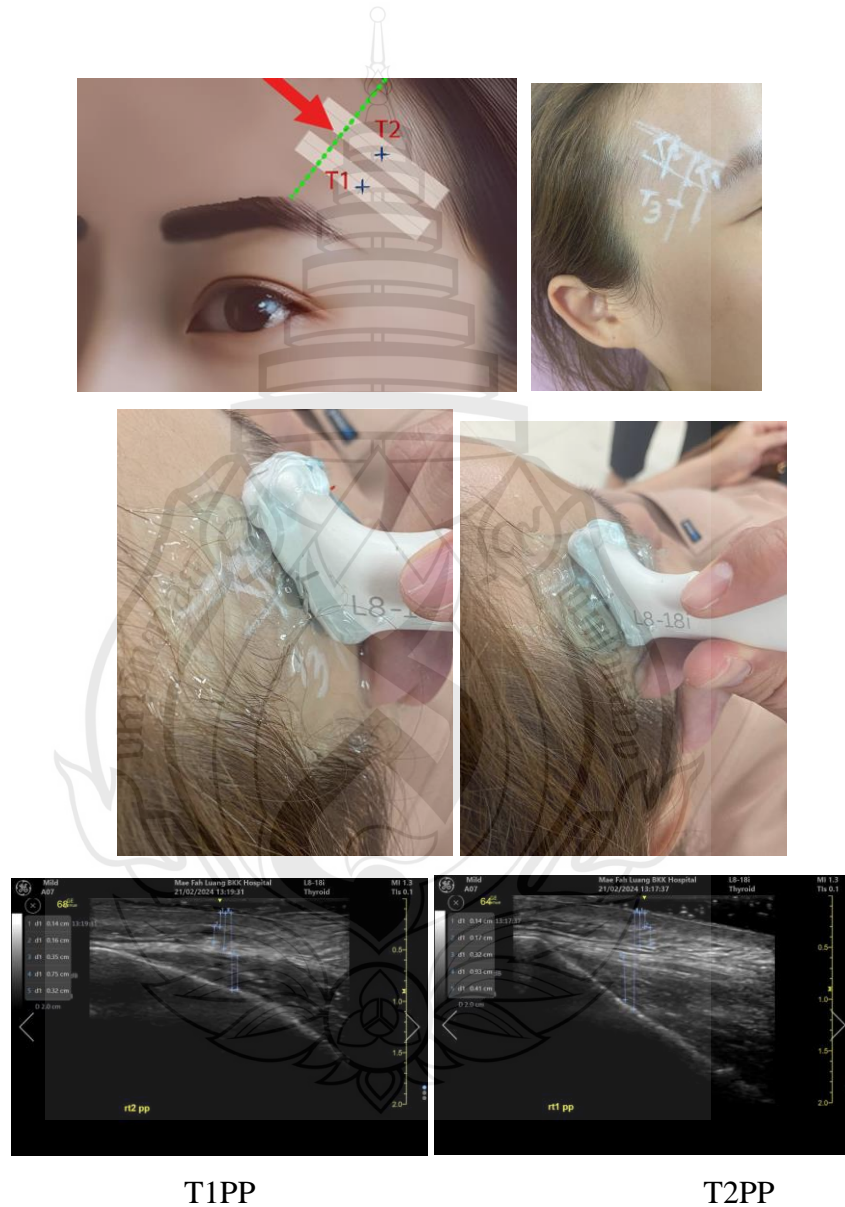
Photo of subject during temporal ultrasound detection perpendicular to the temporal crest at Points T1 and T2 (T1PP & T2PP)
